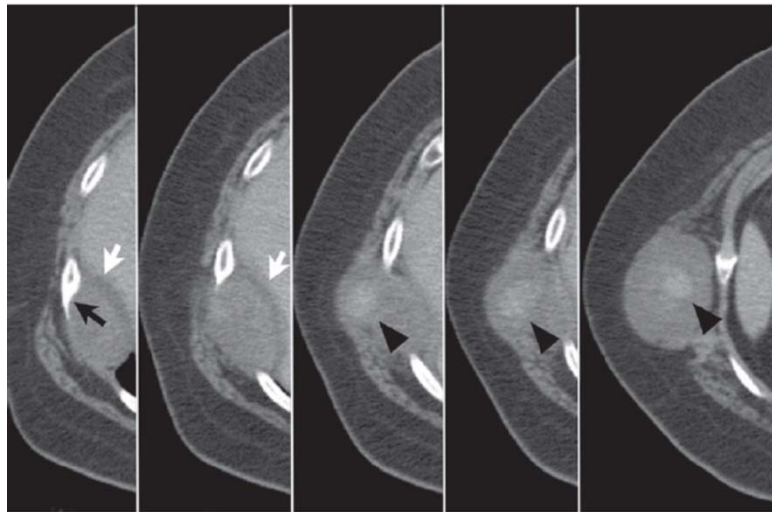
Axial post-contrast CT revealing the inner component of the mass compressing the liver and bulges through the intercostal space into the outer thoracic wall. The tumor erodes the adjacent inferior margin of the 9th rib (black arrow) and shows central enhancement (black arrowheads).
